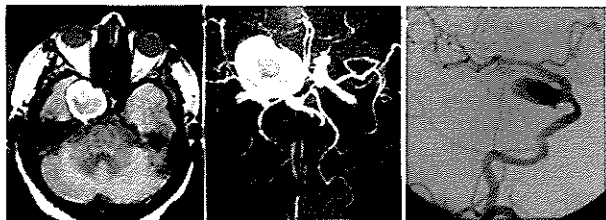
Left: MRI, axial section, showing a large right parasellar mixed intensity lesion, with a high intensity rim. Center: MRA showing a similar lesion at this location. Right: DSA revealed an aneurysm with a smaller patent lumen.
